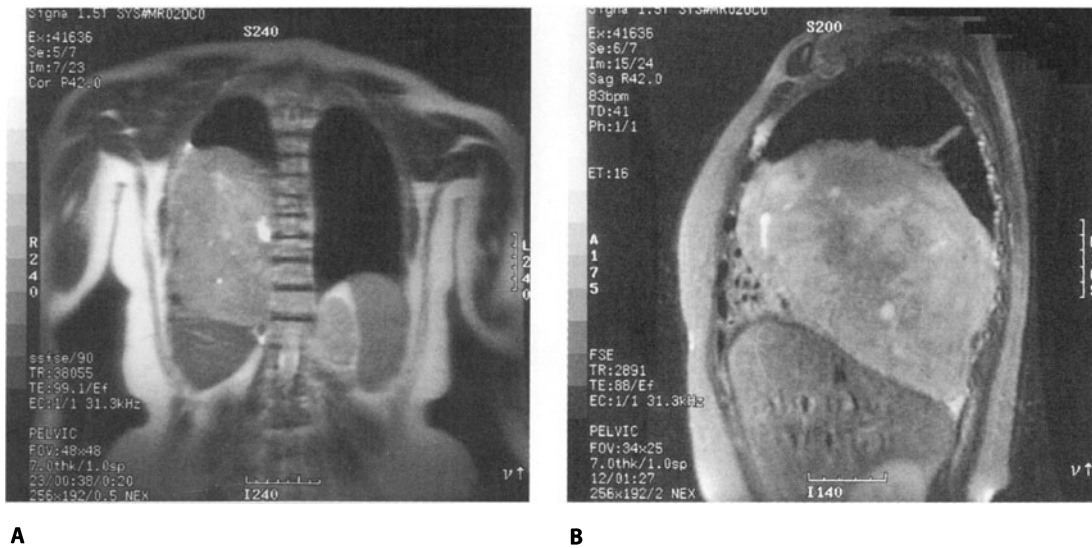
Coronal (A) and sagittal (B) MRI images demonstrate a large benign fibrous tumor of the pleura occupying the greater part of the right hemithorax. This patient presented with complaints of bilateral lower-extremity swelling that proved secondary to inferior vena cava compression. Photograph (C) shows the resected mass that arose from the visceral pleura of the right middle lobe and which was readily separated from the remainder of the lung with a small wedge resection of the affected area.
